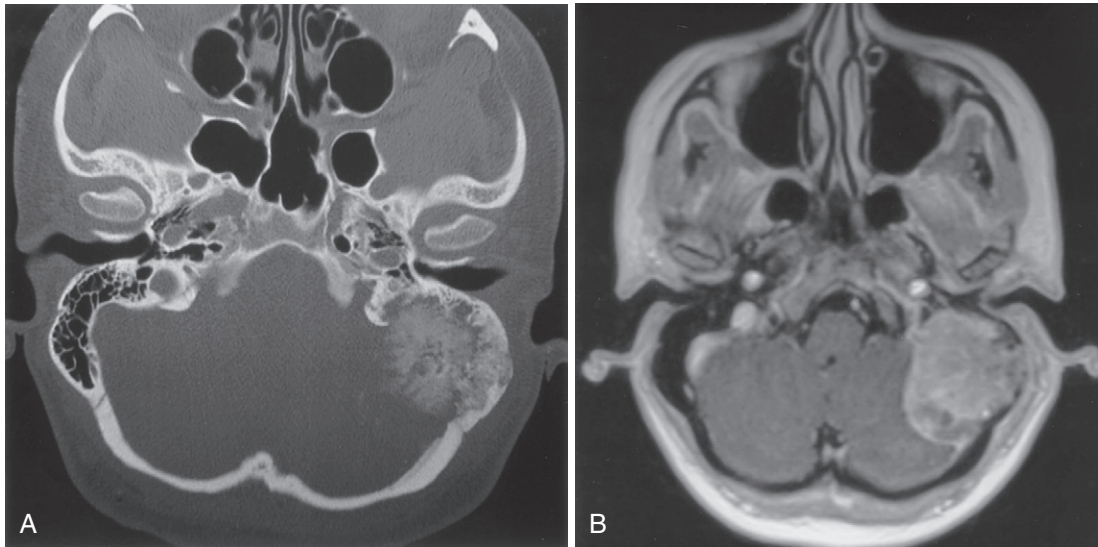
A, CT scan of a 19-year-old woman with osteosarcoma of the left temporal bone and bony destruction of the mastoid. B, MRI is useful for determining the extent of the tumor and the lack of brain invasion. (Courtesy Dr. J. Netterville.)
